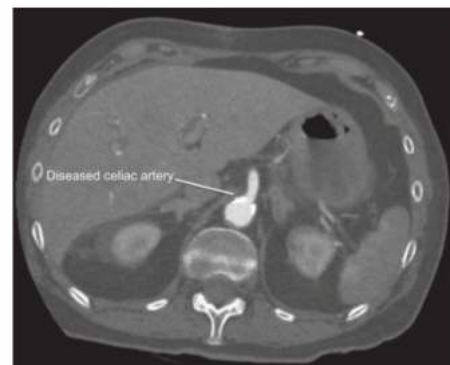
• Axial CT scan image shows a diseased celiac artery origin.
